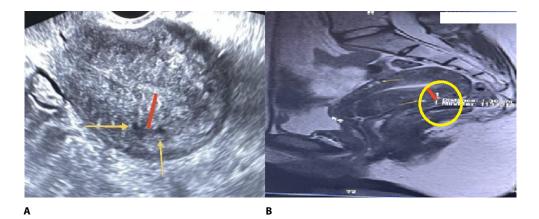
A – Endovaginal ultrasound of 44-years-old female with heavy irregular vaginal bleeding ultrasound show widening of the pseudo junctional zone (red) hyper and hyperintense foci; B – MRI sagittal T 2 of the same patient shows a widening of junctional. Zone. 14 mm red arrow and hyperintense foci yellow arrow
